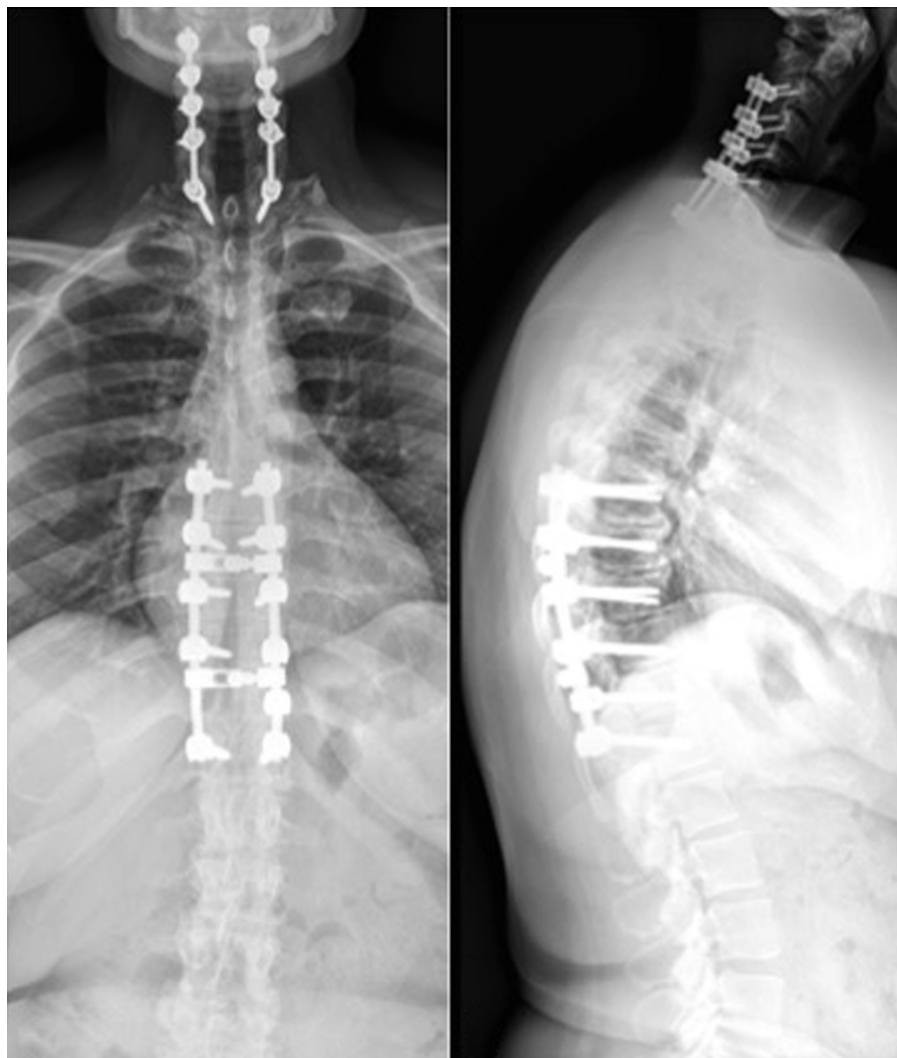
Postoperative (Left) anteroposterior and (Right) lateral plain film radiographs of the thoracic and cervical spines after the first and second stage decompressions with fusion from T7–T11 and C3–T1, respectively.
